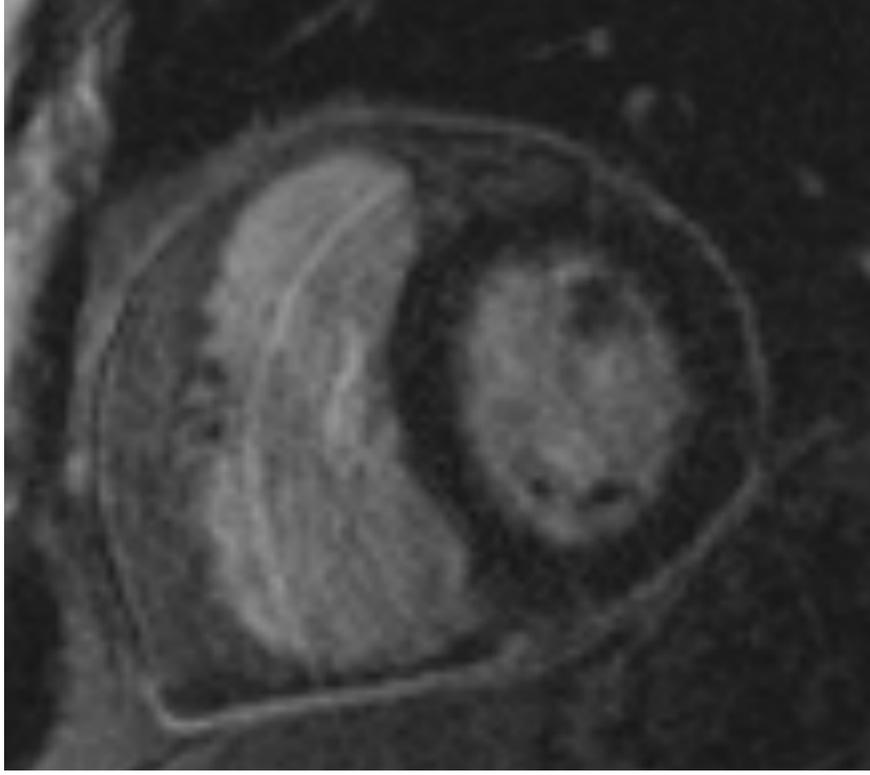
CMR STIR T2-weighted images showing pericardial edema (white arrows).
